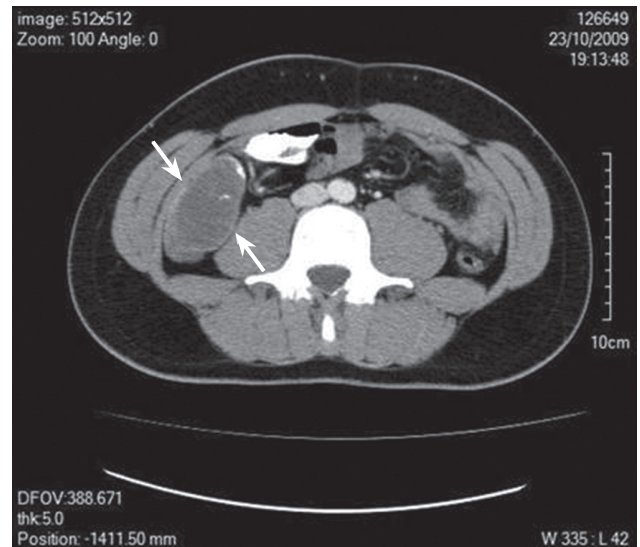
Contrast-enhanced abdominal CT revealing a 10-cm right iliac fossa mass (between the two arrows) with a few calcifications, mildly enhancing post contrast injection, displacing adjacent bowel loops.
